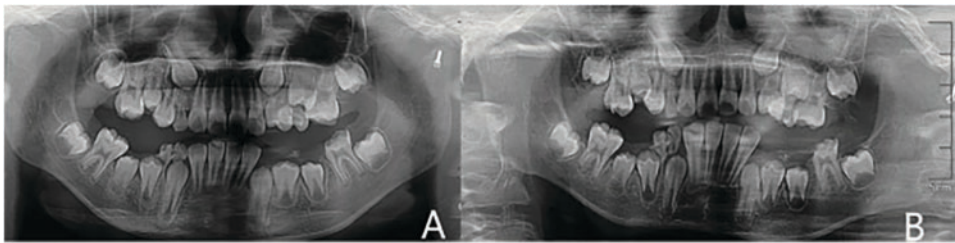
Panoramic radiographs showing mandibular root healing and orthodontic potential
